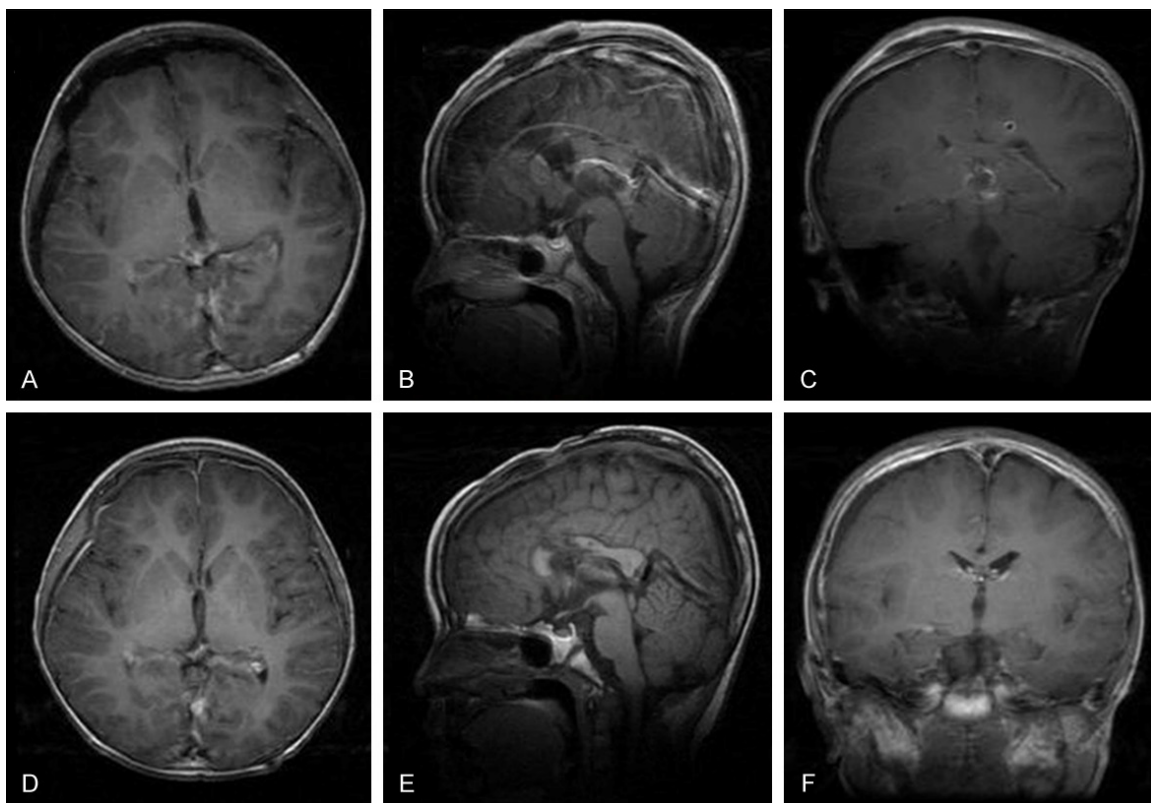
A-C: Postoperative MRI scans showing subtotal removal of the mass lesion in 5 years old patient. D-F: MRI scans 6 months after operation showed no recurrence of the tumor.
